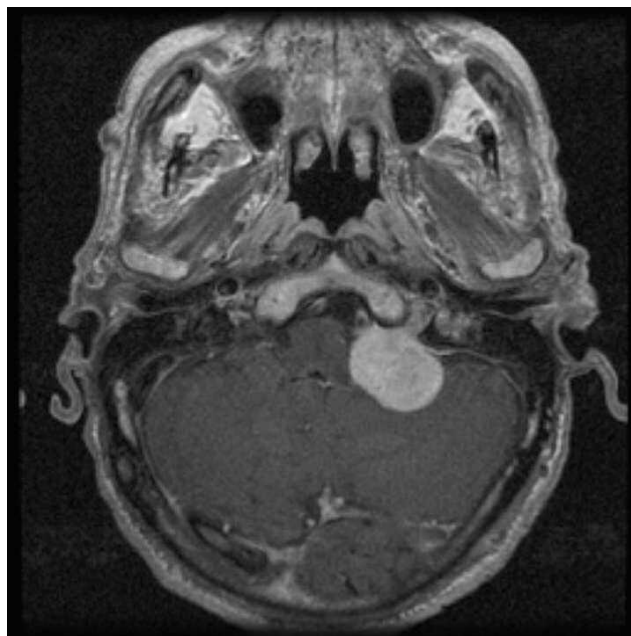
Magnetic resonance image of a patient with vestibular schwannoma.
